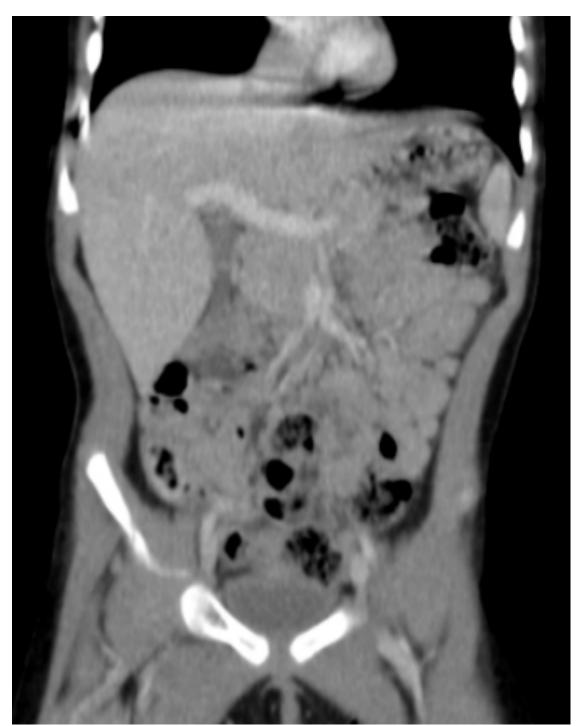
Abdominopelvic CT with IV contrast with no acute intrabdominal process.
